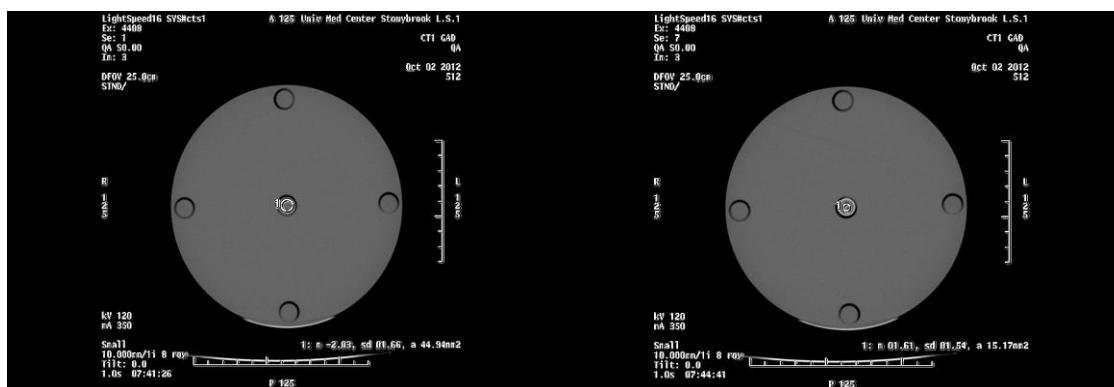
Water Filled Vial on the Left and 0.5 Mm Gd on the Right Showing CT numbers and Standard Deviation
